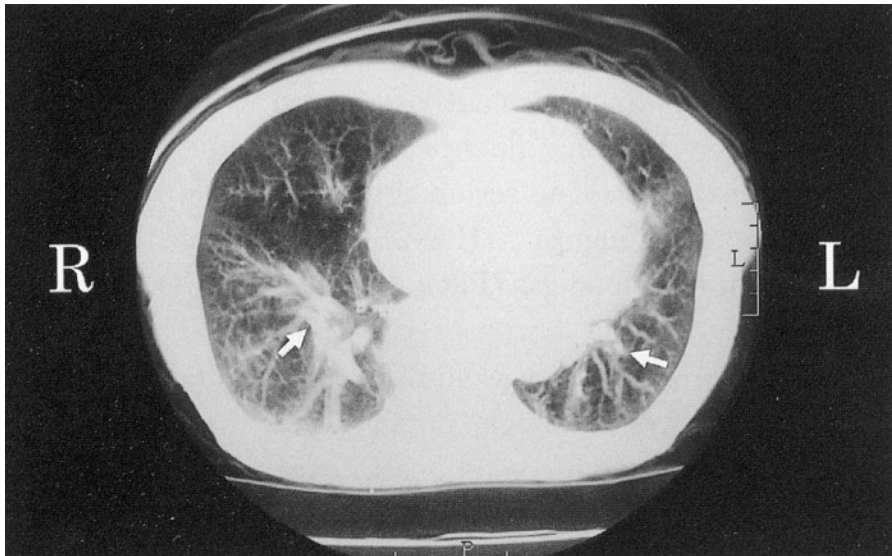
Computed-tomography (CT) scan of the lower chest performed shortly after admission showed dilatation of the bilateral lower pulmonary arteries (arrows).
